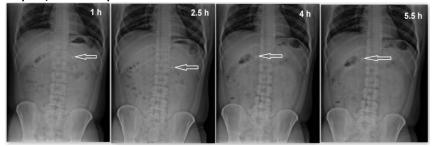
Radiographic images showing the presence of optimized BaSO₄-loaded RSFBT (RSF10) in the stomach of volunteers-1 at different time intervals (the tablet location is pointed out with an arrow).
